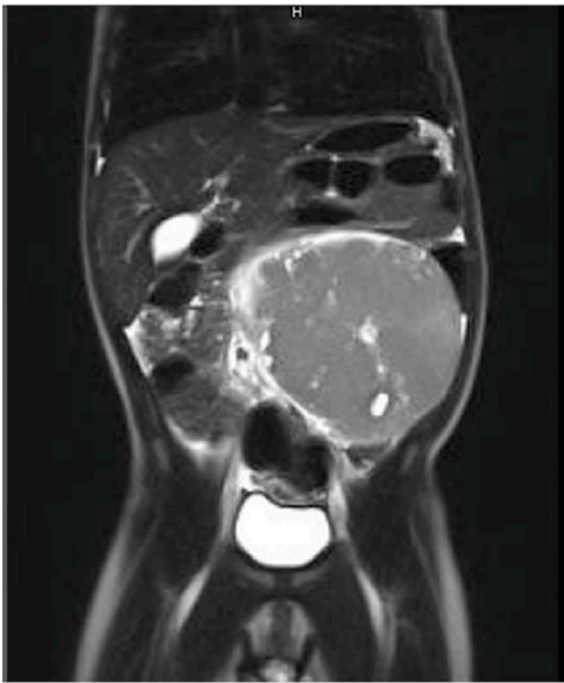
Initial contrast MRI. The coronal image shows a well-defined 11.2 × 12.0 × 2.4 cm tumor of the right ovary.
